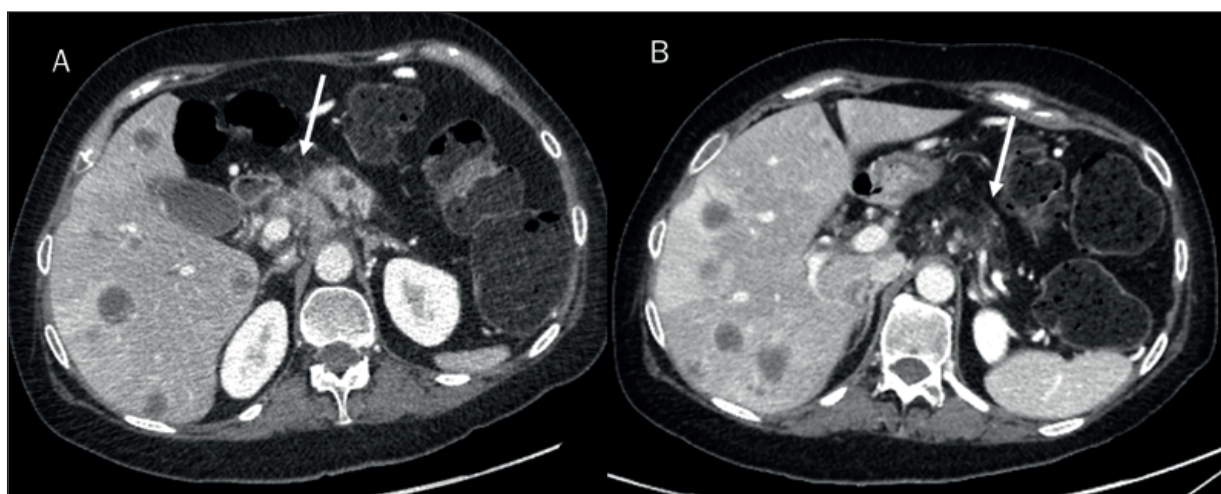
Patient with pancreatic cancer assessed on contrast CT study. In A and B, the arrow shows PC.
